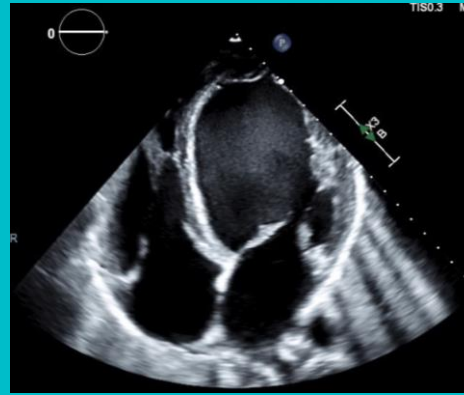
Severely dilated left ventricle by 2D transthoracic echocardiogram
